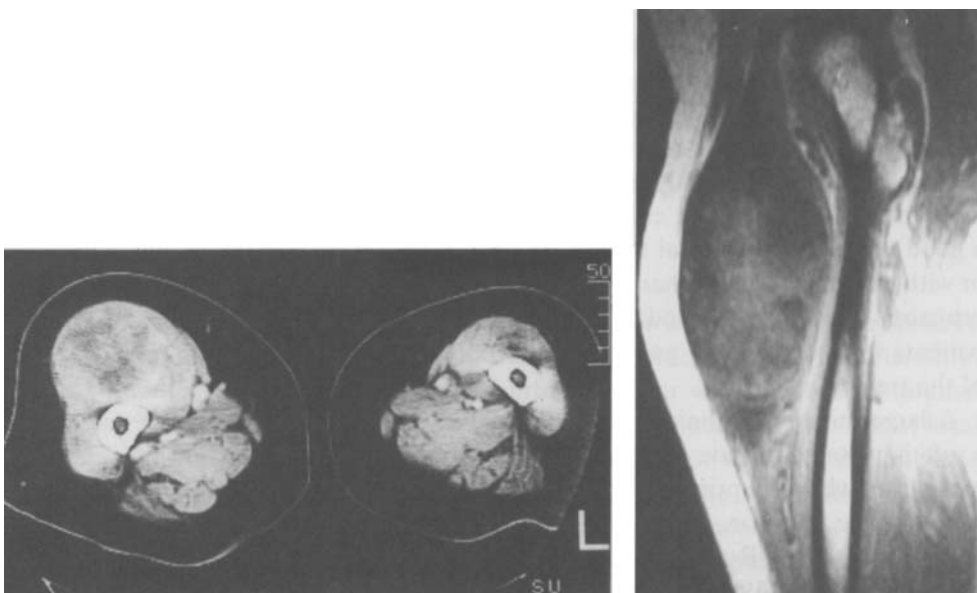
A Grade IV malignant fibrous histiocytoma located in the right rectus femoris muscle of an 86-year-old woman. Computed tomogram (left), magnetic resonance tomogram (right). The patient was referred with a virgin tumor and surgery, with excision only of the rectus muscle (primary myectomy), was performed after fine-needle aspiration cytology showed sarcoma. No adjunctive therapy was given. There was no evidence of disease and no functional deficit 1 year after surgery (see also cover).
